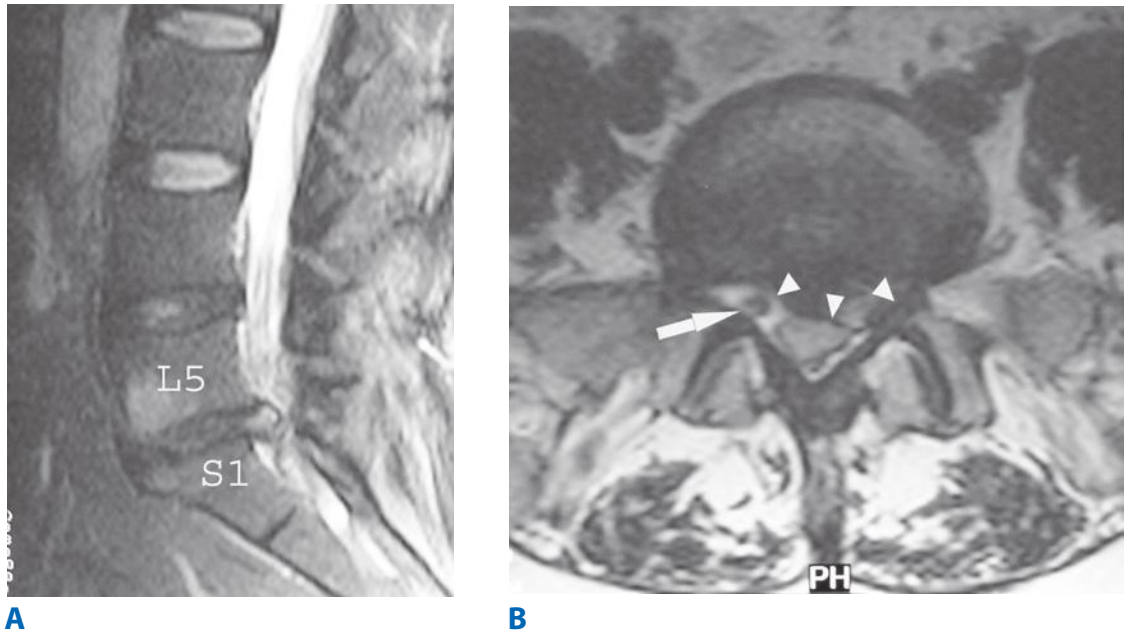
A. T2-weighted sagittal magnetic resonance imaging shows an L5–S1 disc herniation causing significant canal compromise and displacement of nerve roots. B. T2-weighted axial magnetic resonance imaging of the same patient shows the large left paracentral disc herniation at L5–S1. Arrowheads delineate the extent of the herniation. The arrow indicates the right S1 nerve root passing through free of compression. The left S1 nerve root is under severe compression and is not seen.
